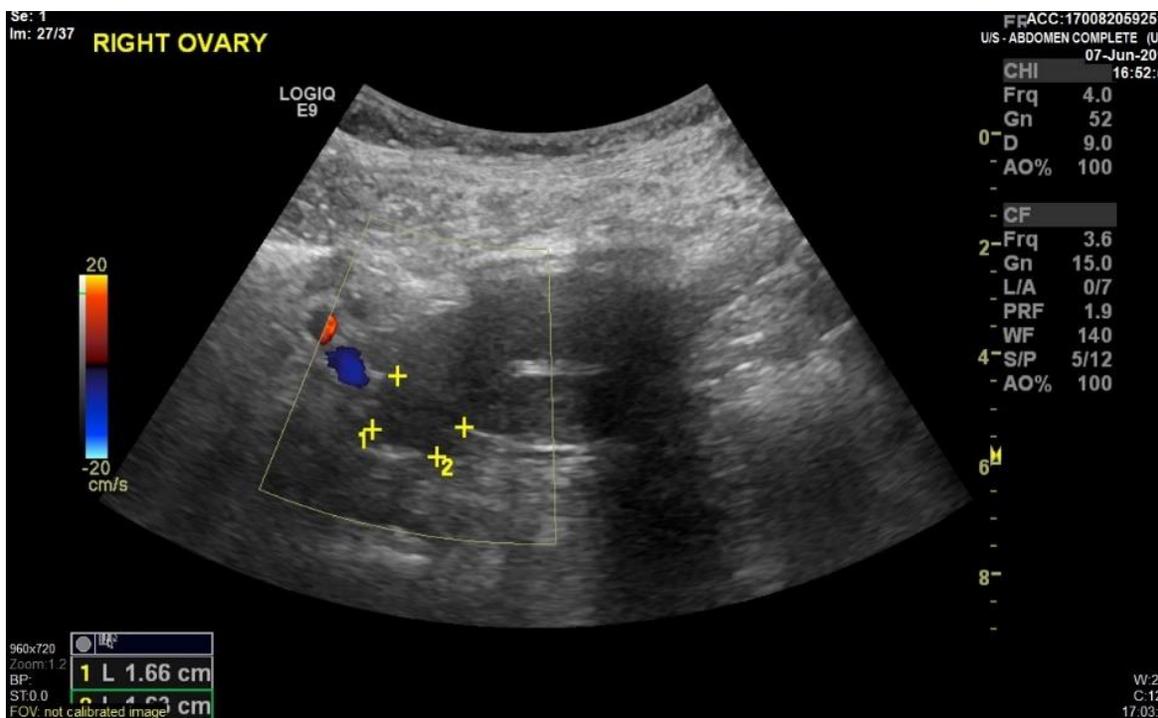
Ultrasound showing normal pelvic structures. No intraabdominal pathology was found.
